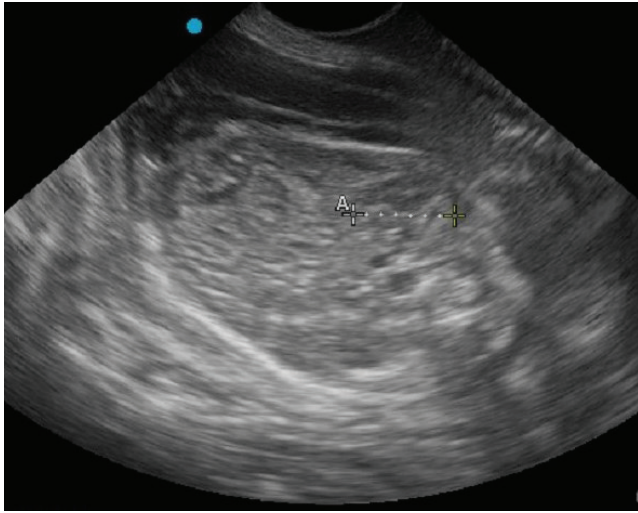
Transabdominal ultrasonographic image of a canine fetal kidney (outlined with caliper), note the degree of architectural detail indicates progression of fetal maturity.
